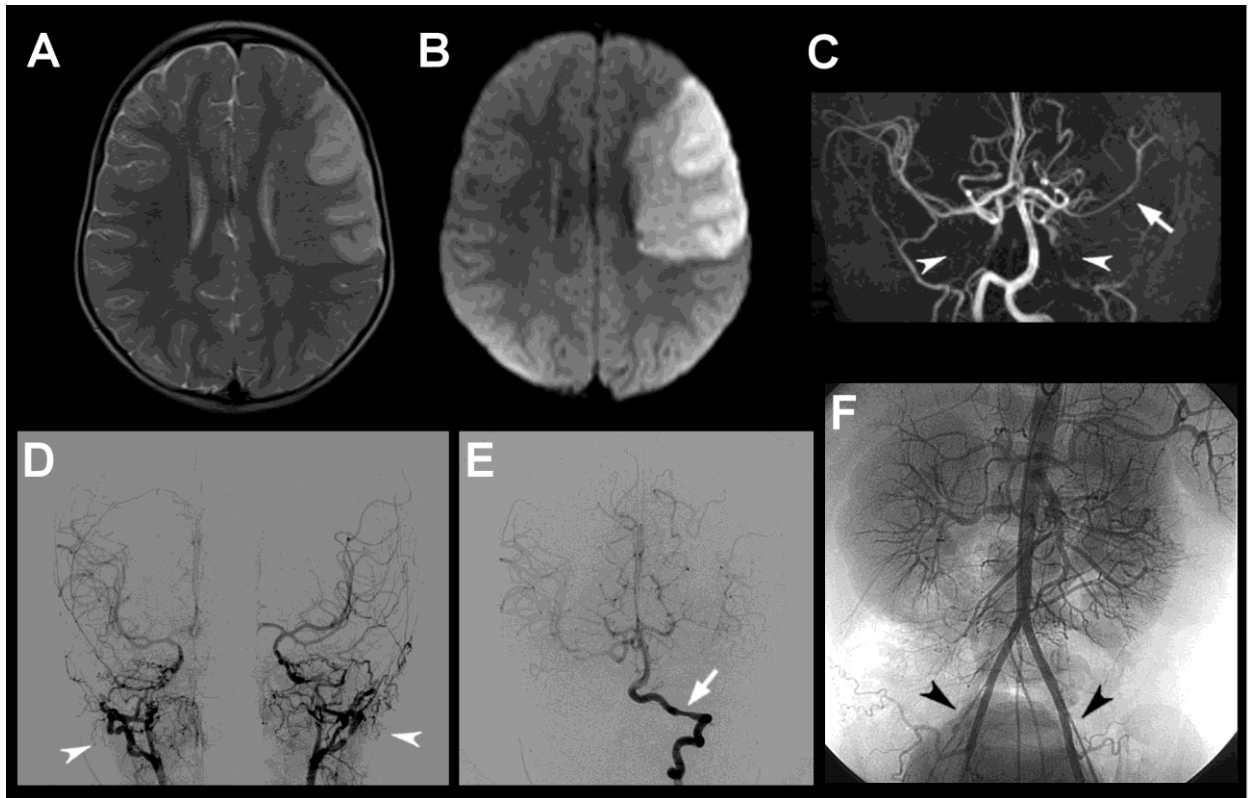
Neuroimaging of patient #17. Brain MRI (A, B), MRA (C) and Digital Angiography (D,E) with AIS in the left MCA territory, non-inflammatory MCA arteriopathy and bilateral segmental ICAs agenesis with carotid rete mirabile. Abdominal MRA (F) with evidence of a multisystem stenotizing arteriopathy (iliac arteries).
